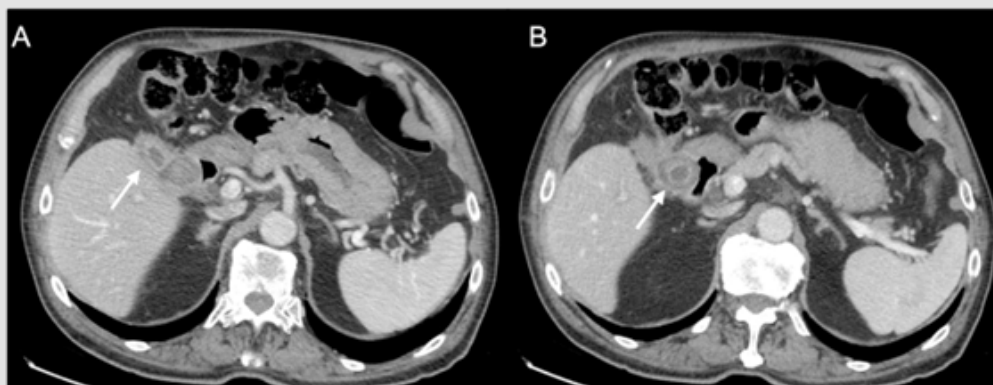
Contrast-enhanced CT scan demonstrates the presence of thickening of gallbladder wall (Figure 1A, arrow) and the presence of a 3 cm gallstone abutting on the second portion of duodenum (Figure 1B, arrow).
